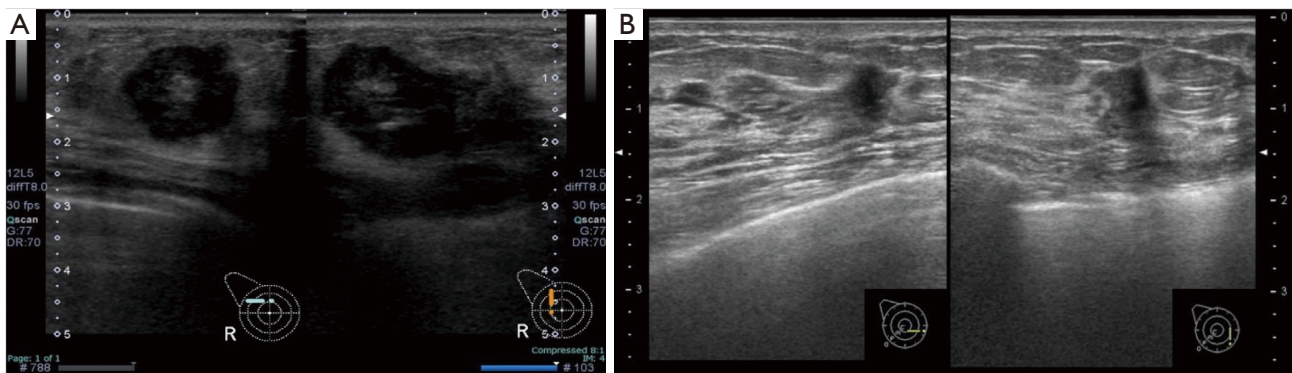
Pretreatment ultrasonography. There is a hypoechoic mass in the right upper-outer quadrant (A). Another hypoechoic lesion is observed in the right lower inner quadrant (B).
